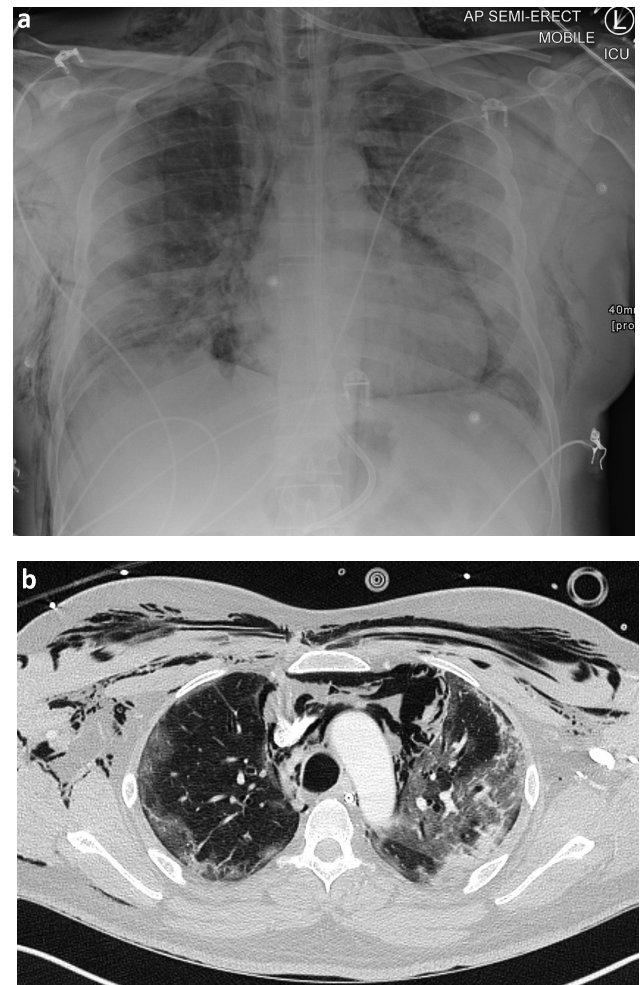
a) Chest X-ray showing pneumomediastinum and SARS-CoV-2 pneumonia. b) Computed tomography showing subcutaneous air leak and parenchymal changes of severe COVID-19.
